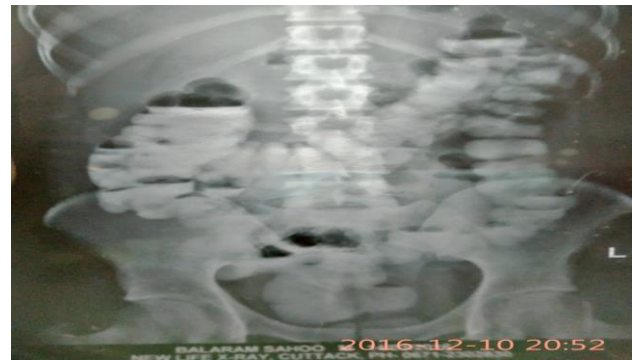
X-ray showing passage of urografin to colon.
